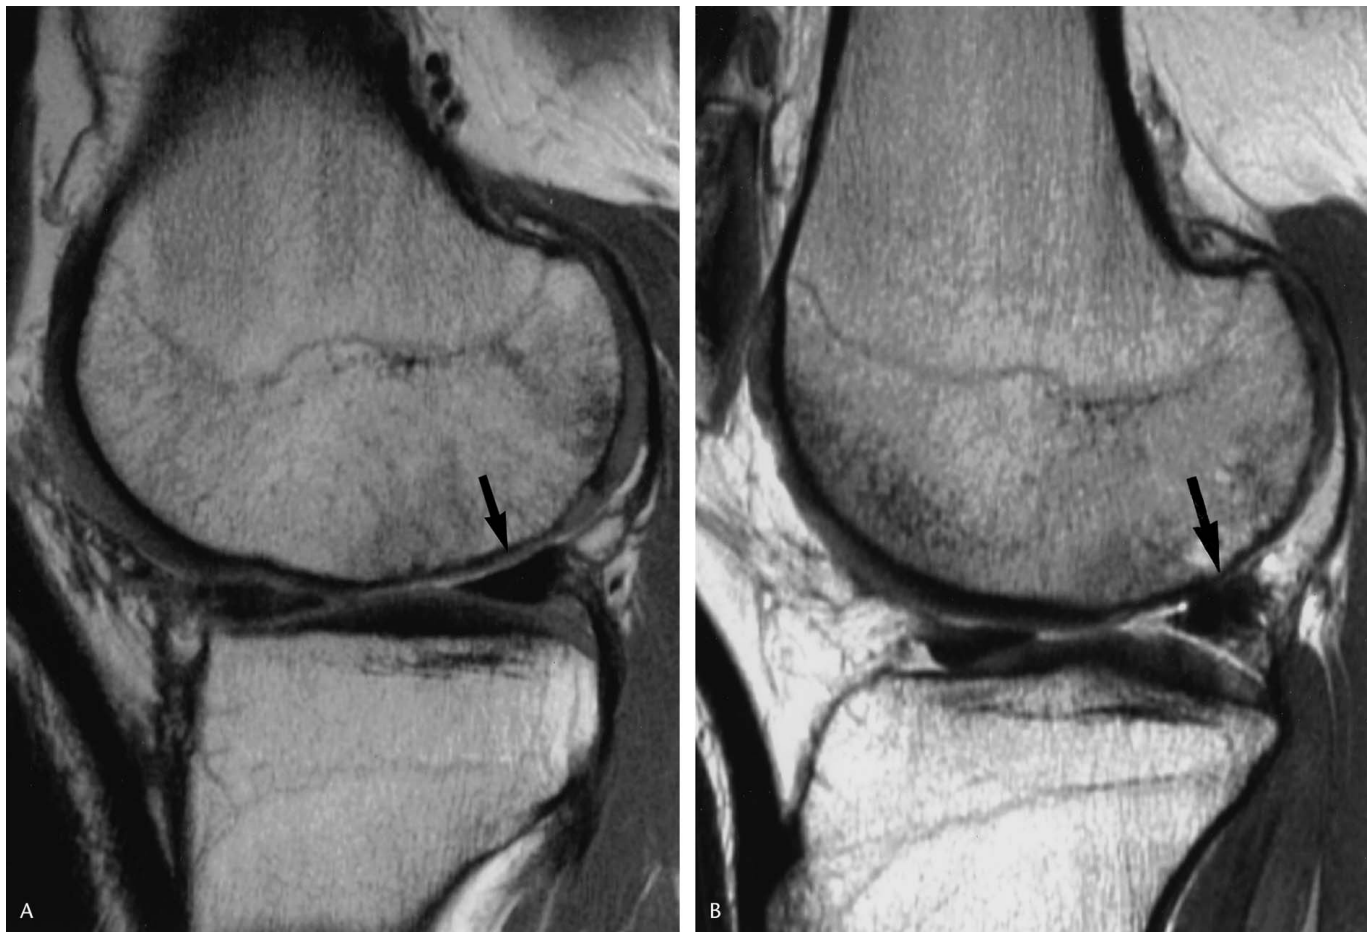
Sagittal MRI scans of a 30-year-old man were obtained (A) 3 months and (B) 15 months after microfracture. Figure 4A shows a thin rind of hyperintense reparative cartilage (arrow), which is depressed with respect to adjacent cartilage. Figure 4B shows little remaining repair cartilage over the posterior aspect of the lateral femoral condyle with irregularity of the subchondral plate (arrow).
